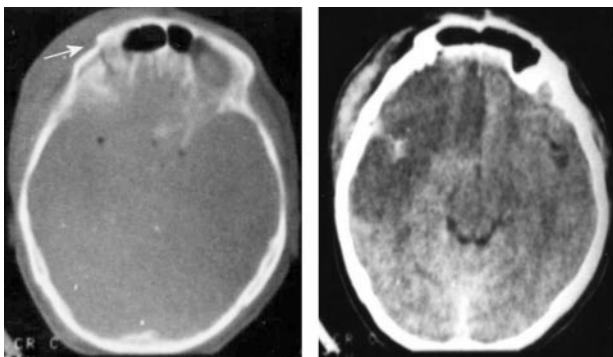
CT axial (bone and parenchyma window) on the left frontal-skull fracture, on the right subgaleal hematoma (arrow)
